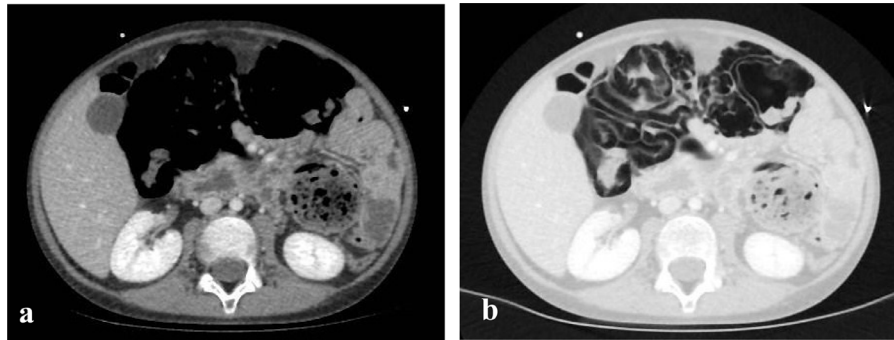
Axial abdomen contrast-enhanced CT images in the soft-tissue window (A) and lung window (B) confirm the presence of pneumatosis cystoides intestinalis of the transverse colon and hepatic flexure.
